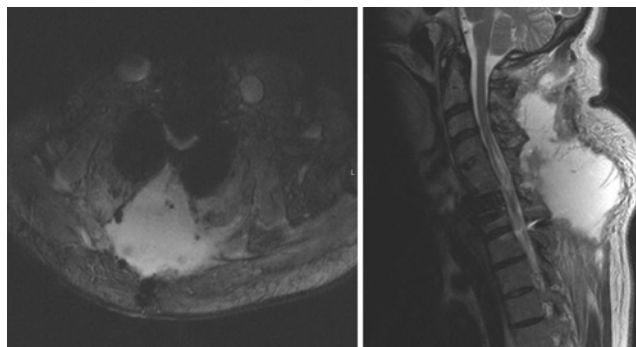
Case 2. Postoperative axial (left) and sagittal (right) T2-weighted MR image of the cervical spine showing a significant fluid collection overlying the C2–T1 levels consistent with a seroma.
